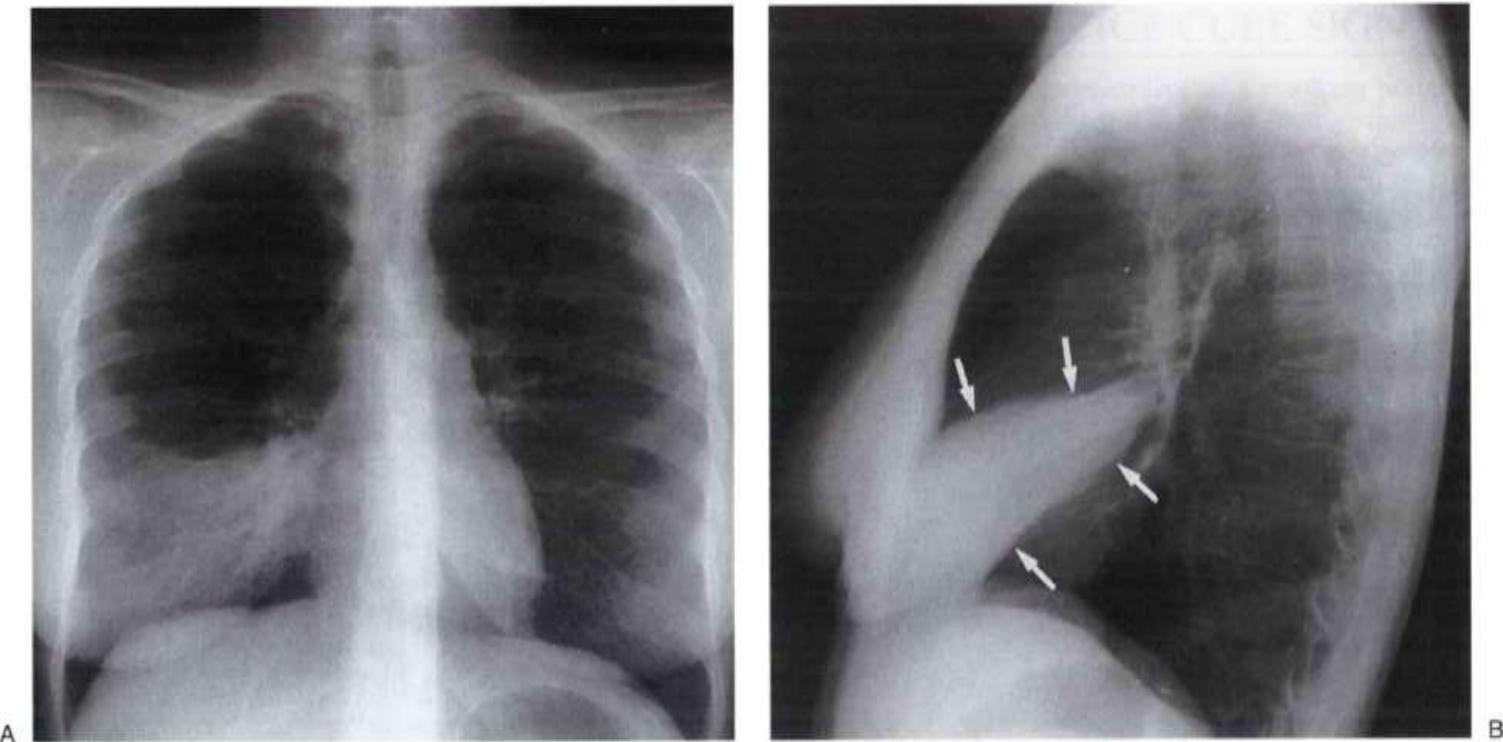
Silhouette sign. A: PA chest radiograph of a patient with pneumococcal pneumonia shows opacification of the right lower lung, which partially obscures the right heart border (the silhouette sign), indicating a process involving the right middle lobe. B: Lateral view shows a triangular opacity over the heart (*arrows*), confirming a right middle lobe process.
